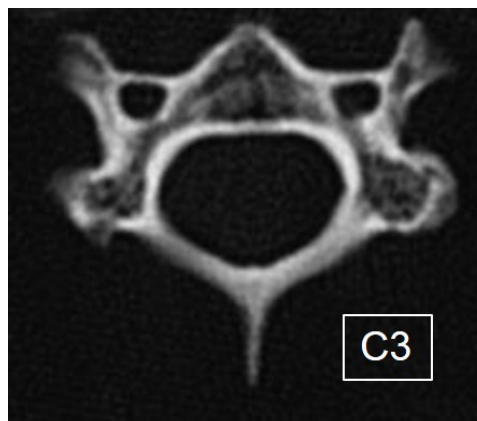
Multiplanar reconstructions of the CT of the *M. fascicularis* spine with labels indicating cervical (C1-C7), thoracic (T1-T12), and lumbar (L1-L6) vertebrae. Caudal vertebrae (proximal 4) are also seen below the sacrum. As a result of scanning without supporting discs or soft tissues, the vertebrae are not precisely aligned in these images.
